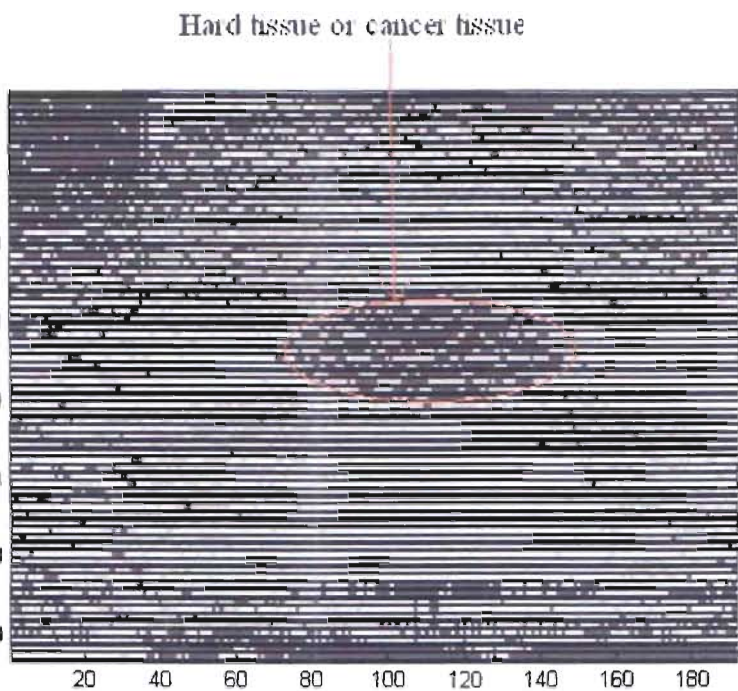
B-mode elasticity image for real ultrasound data using frame compression technique.
